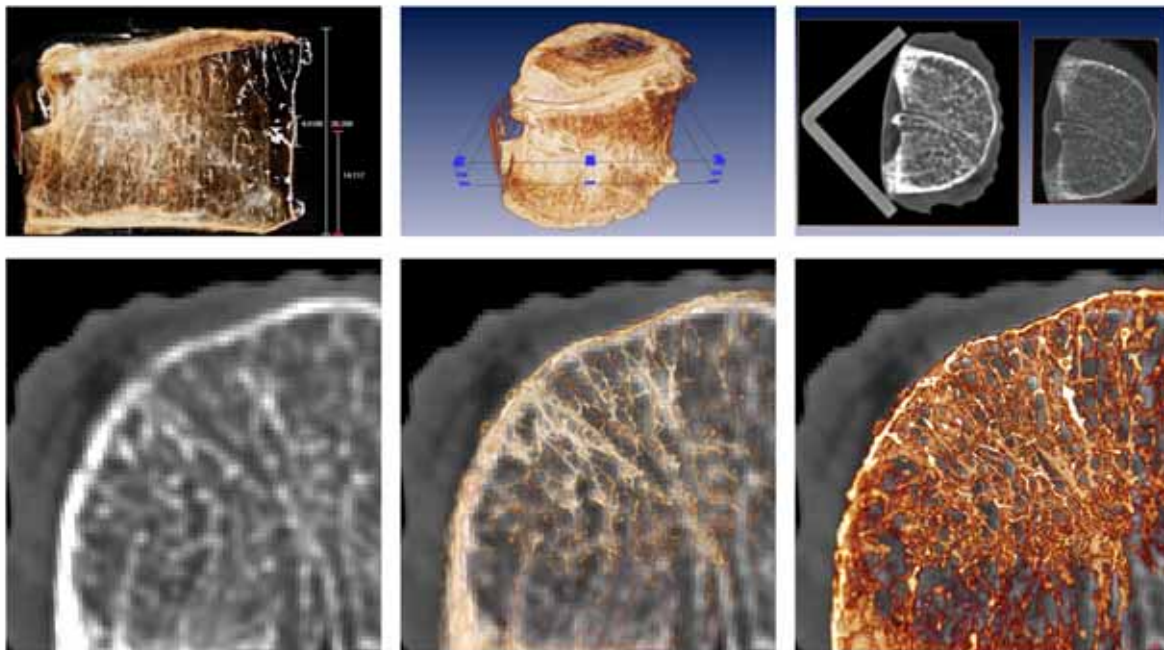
Comparison of image data acquired with a whole-body CT scanner and data acquired using a μ CT. Top row: A central 4 mm thick slice is selected and averaged in z direction. The 4 mm slice from the standard CT scanner is visually matched. Left: Orthogonal side view with measurement tools (length in mm). Center: A sub-volume is selected using an interactive dragger. Right: The slice from the μ CT (right) is compared to the slice from the CT scanner. Bottom row: After matching the slice location, the internal bone structure can be directly compared with the CT slice. Left: CT slice. Center: CT slice overlaid with transparent volume rendering. Right: Volume rendering showing the rich trabecular structure – only part of it at full resolution.
